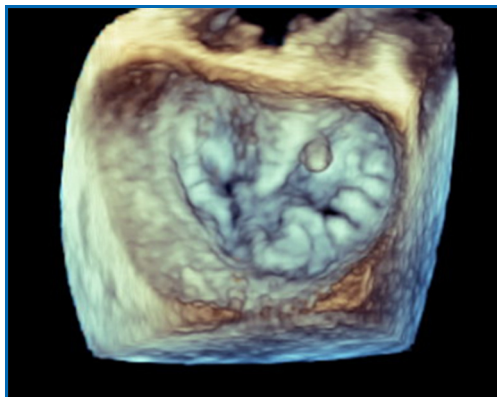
Transesophageal echocardiogram of mitral valve lesion, located on the medial aspect of A2 cusp.
